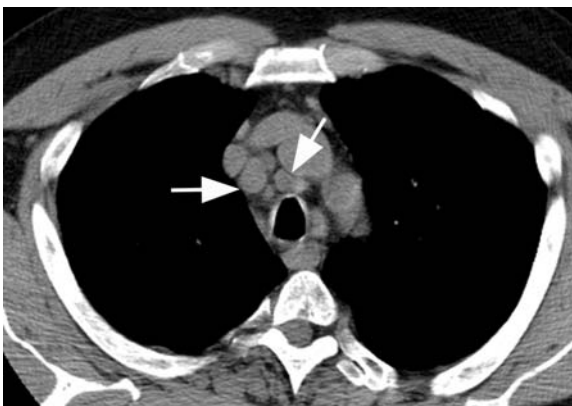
Computed tomography image obtained just above the aortic arch in a patient with chronic beryllium disease shows multiple moderately enlarged pretracheal and paratracheal nodes (arrows)
